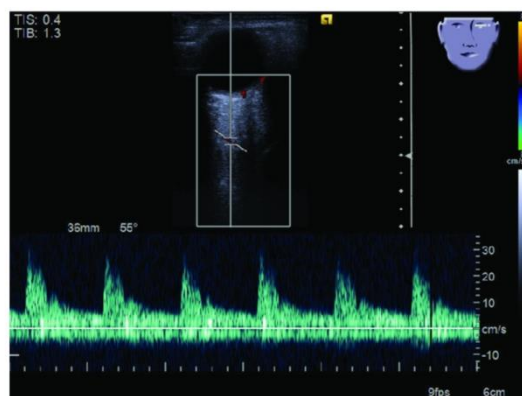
Normal Color Doppler image and waveform on an OA
